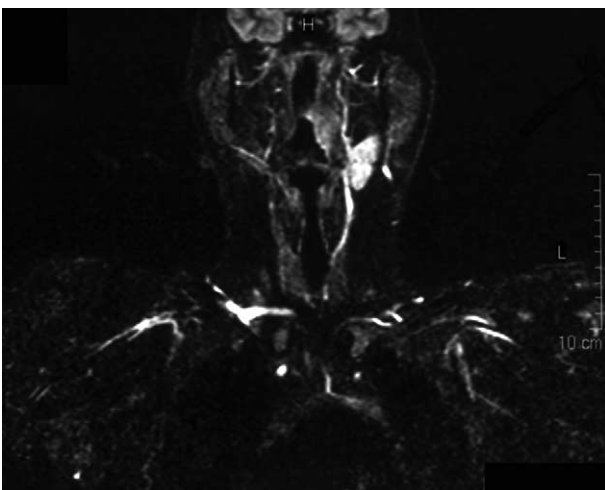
Magnetic resonance (MR) scan demonstrates a well-circumscribed, lobulated, lesion with non-uniform high signal intensity with increased vascularity on T2-weighted images without infiltration of the surrounding tissue.
